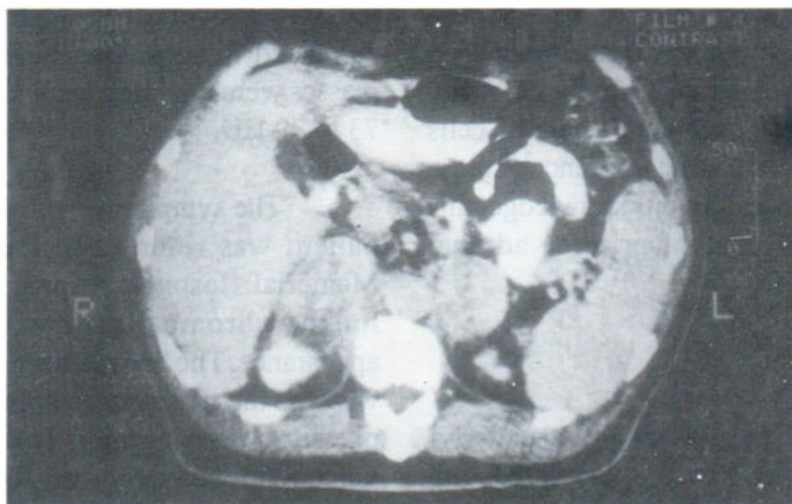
Contrast-enhanced CT scan shows inhomogeneous enhancement of bilateral adrenal masses.
